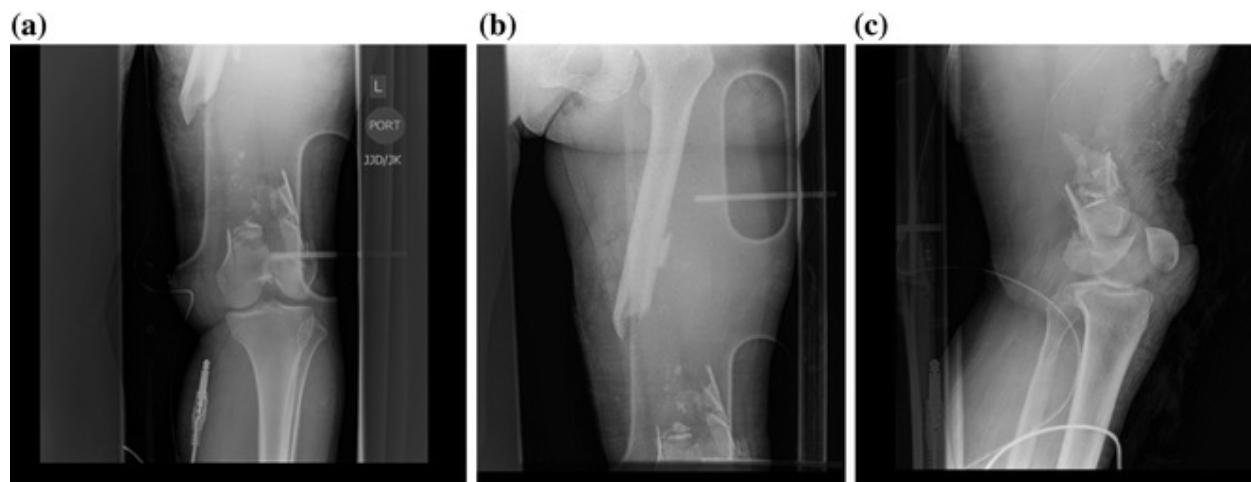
Initial injury X-rays (a–c)
